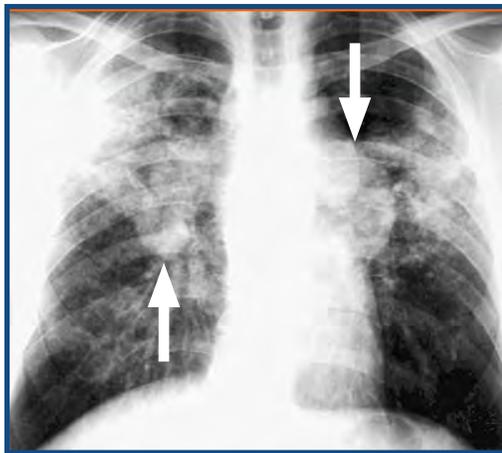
Chest radiograph of Stage II Sarcoidosis – enlarged lymph nodes (arrow pointing up) and involvement of lung tissue (arrow pointing down)
